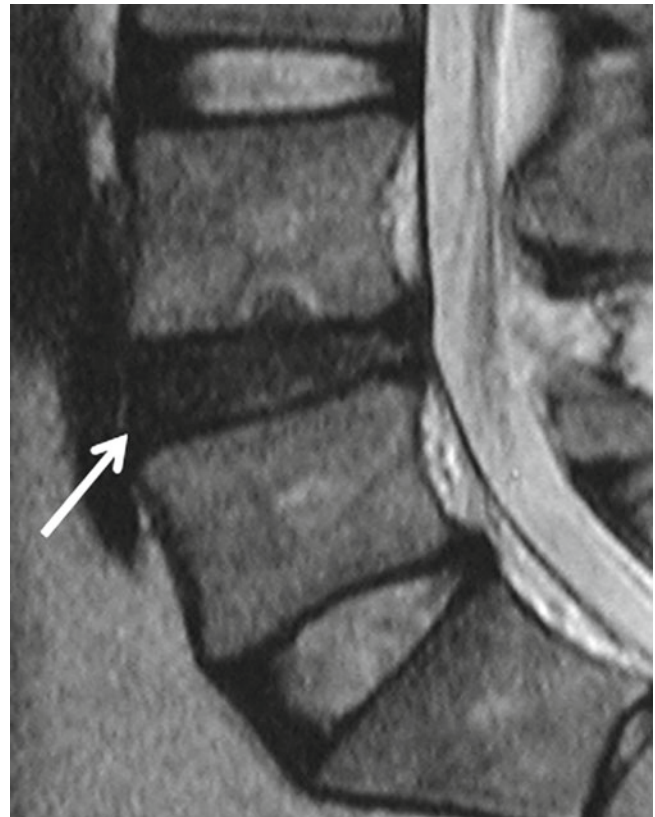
Sagittal T2-weighted lumbar MRI image demonstrating degeneration of the L4–5 intervertebral disc (*white arrow*). Water has high signal intensity on T2-weighted MRI imaging. As the disc degenerates, it loses its water content and, as such, loses its high signal intensity compared to the healthy disc. The degenerative disc becomes grey or black and is often referred to as a “dark disc.” Note that the L3–4 and L5–S1 discs above and below the L4–5 level still have high signal intensity
